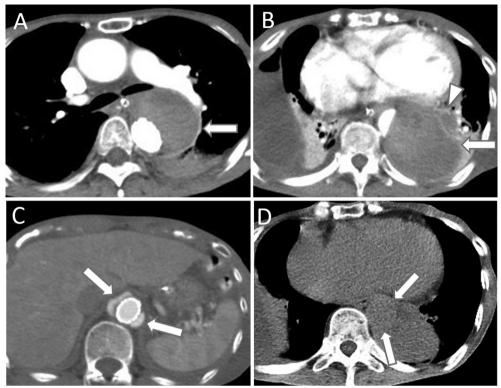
Computed tomography images (A–C) 3 days and (D) 4 months after thoraco-abdominal aortic aneurysm repair. (A, B) A patent thoracic false lumen (FL) was completely thrombosed (arrows), including the rupture site (arrowhead). (C) Coeliac level. Although the FL was not thrombosed (arrows), significant FL shrinkage was obtained. (D) After 4 months, further shrinkage of the thoracic FL was observed compared with the previous image at the same section B. The true lumen was fully expanded (arrows).
